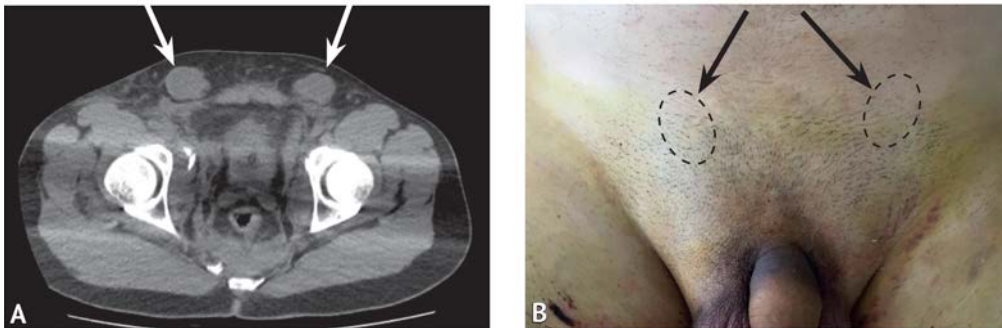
Computed tomography image of bilateral testicular dislocation in the pubic region at the level of rectus abdominis attachment (A); localization of the testicles in the same patient during palpation (B)
